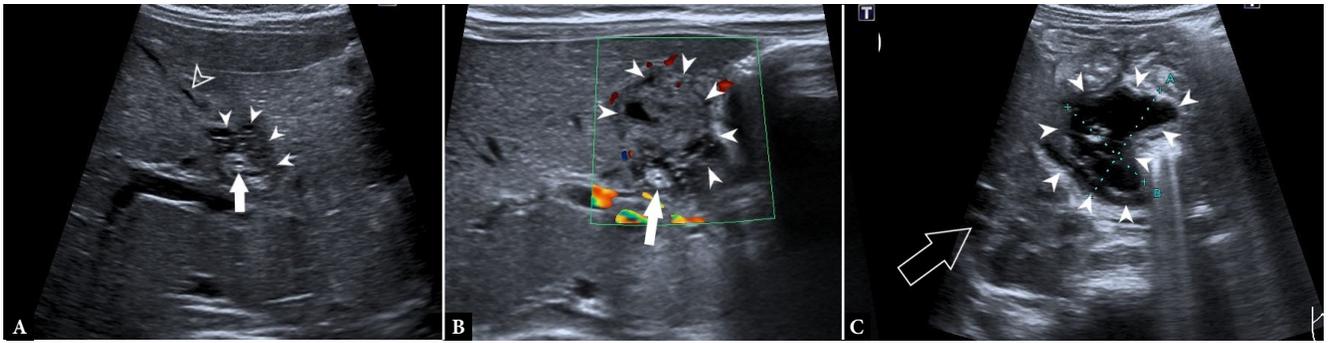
Ultrasound findings suggestive of biliary perforation in second patient on admission: A. and B. beginning of the septated collection in the hepatoduodenal region (arrowheads), concentric thickening of the distal common biliary duct (arrow), and contracted gallbladder (empty arrowhead), C. extension of the fluid collection (arrowheads) down to the level of the right kidney (empty arrow) in the anterior pararenal space
